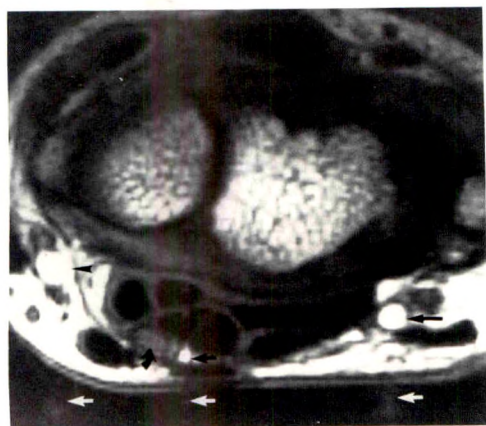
Persistent median artery. Axial MR image (TR 600, TE 25) in normal volunteer. Left wrist viewed toward elbow with palm down. Persistent median artery (short straight black arrow), median nerve (curved arrow), radial artery (arrowhead), ulnar artery (long straight black arrow), and flow artifact from three arteries (white arrows).
